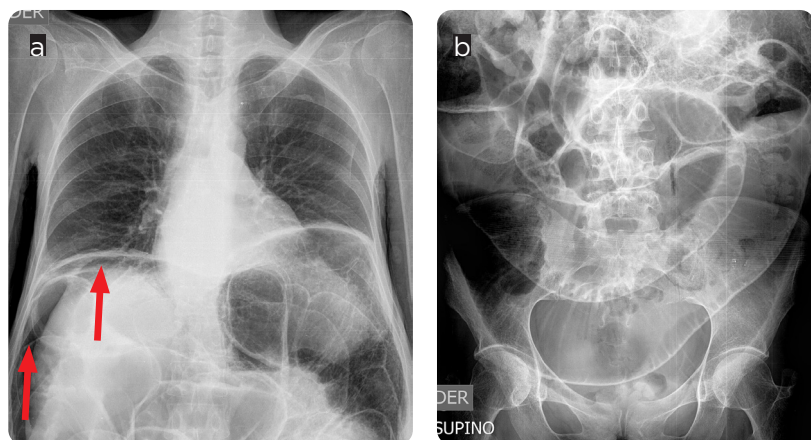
39-year-old patient with history of scleroderma, admitted for abdominal pain. a and b) Abdominal radiography with distension of thin and colonic intestinal loops with pneumoperitoneum (arrows).
